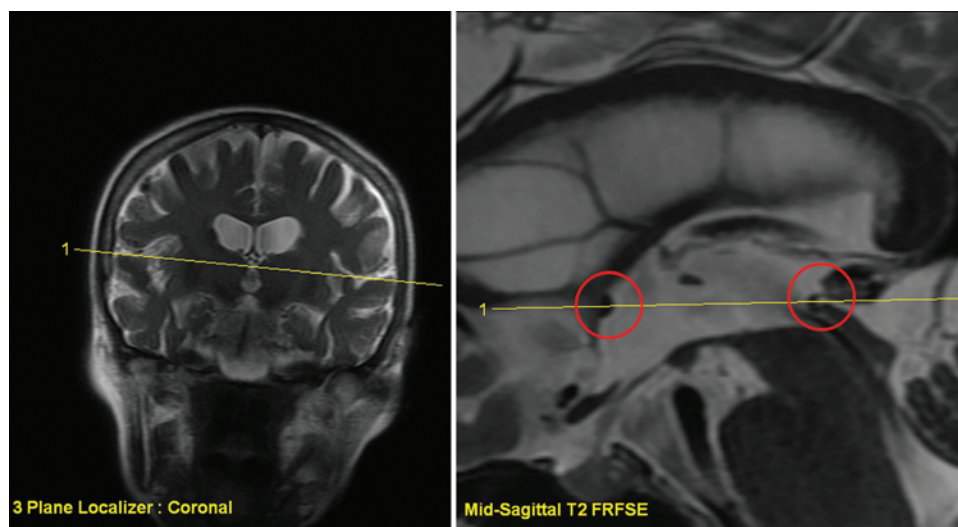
Magnetic resonance prescription of the T2-weighted FRFSE midsagittal scan on 3-plane localizer images. The angles of rotation (right) and tilt (left) of the head have to be taken into account and the prescription lines positioned accordingly, passing through the center of the third ventricle.
